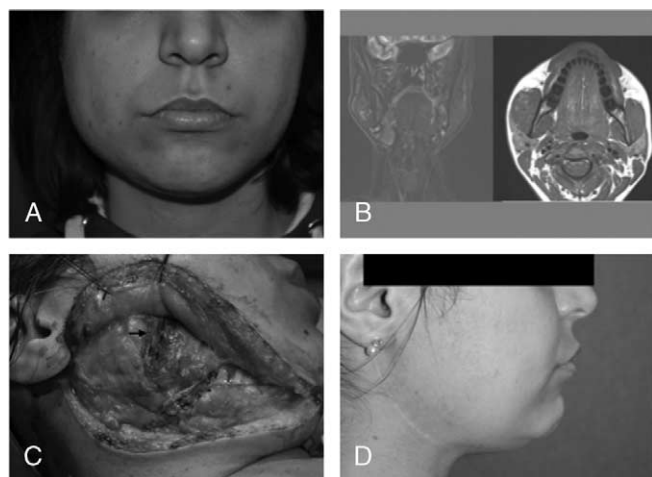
A, Preoperative photograph of a 27-year-old woman showing swelling and asymmetry on the lower right side of the face. B, Magnetic resonance image of the neck. A coronal section (left) demonstrates a contrast-enhanced lesion that causes bulging of the right masseter muscle. An axial section (right) of the MRI demonstrates a lesion with ill-defined borders within the right masseter muscle. C, The intraoperative picture shows the site of incision, the plane of the skin flap, and the vertical incision through the masseter muscle (arrow). D, Postoperative second-year photograph of the patient shows a well-healed incision scar along the mandibular border.
